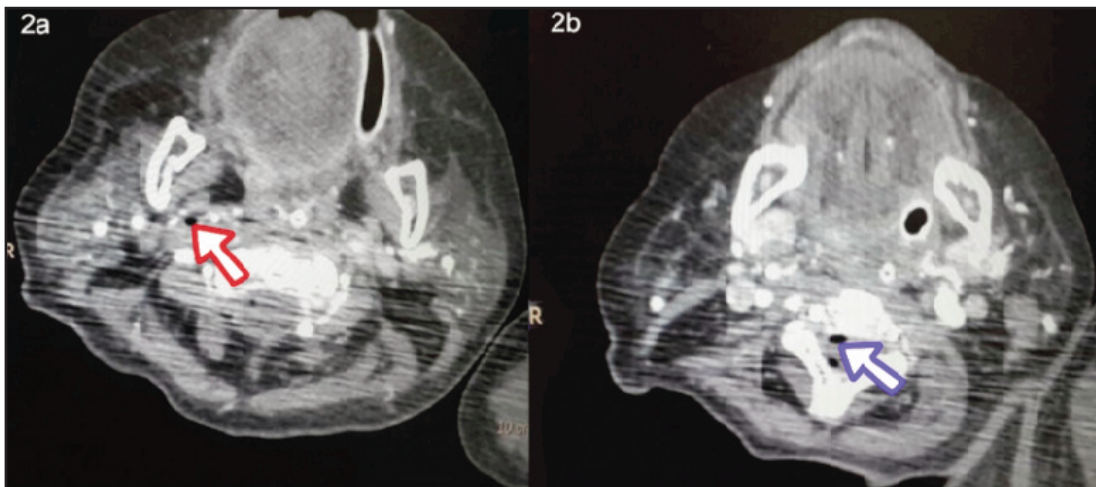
Computed tomography (CT) angiogram of the level of neck showing air foci in the right common carotid artery (arrow in 2a) and epidural CSF spaces in the cervical cord level (arrow in 2b).
